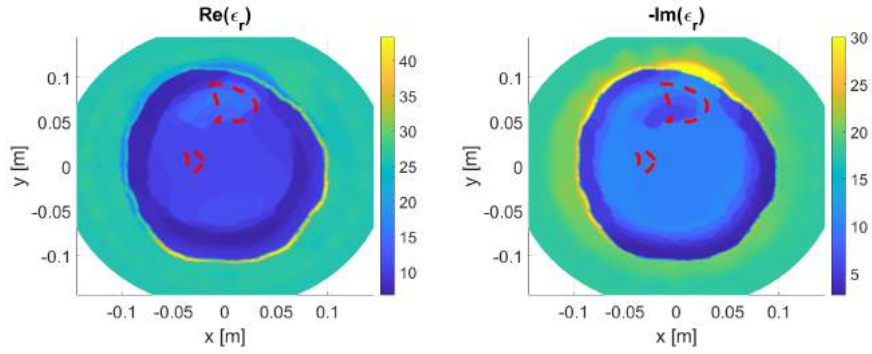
Incorporating prior info to enhance MRI model 1 reconstruction.
